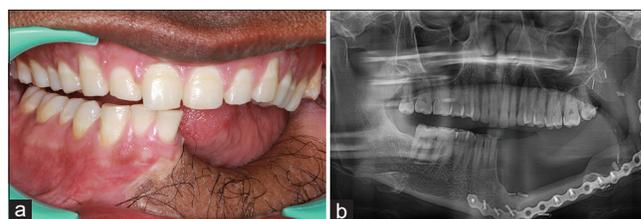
(a) Intraoral view showing missing 31–37. (b) Postsurgical panoramic radiograph showing reconstructed left mandible with a screw plate system used for fixation and osseous graft
